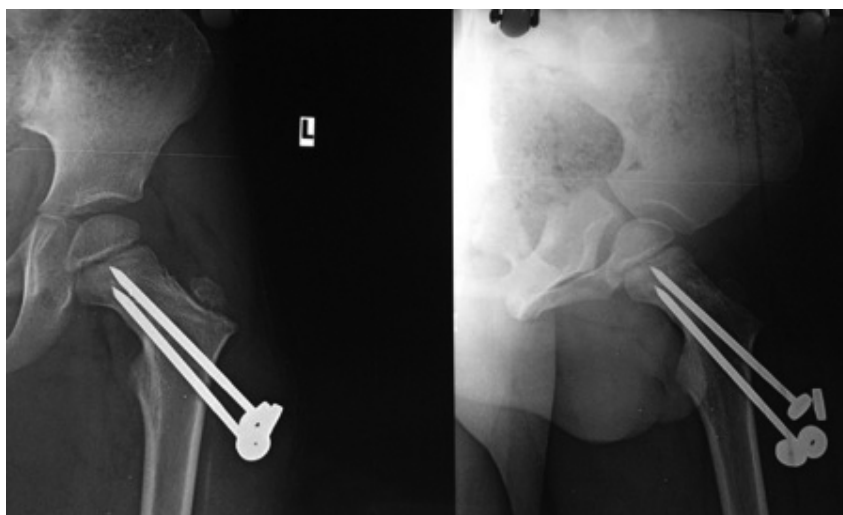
A) At 3 months, fracture shows evidence of union B) AP radiograph at 6 months of follow up.
